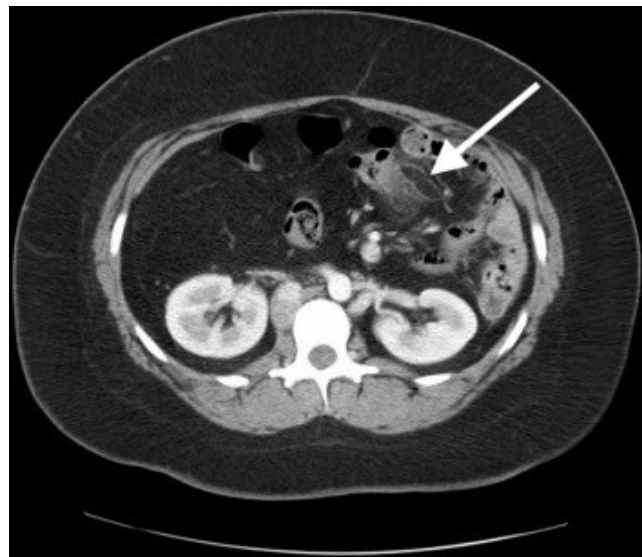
Computed Tomography: A 23 year-old female patient with epiploic appendagitis shown on axial CT with IV and rectal contrast. The epiploic appendagitis is shown as a 2.8 x 0.8 cm fat attenuated mass surrounded by inflammatory changes, which is shown by the arrow. (Radiocontrast 100cc IV dose of Iohexol 350 mg and gastrografin enema).
